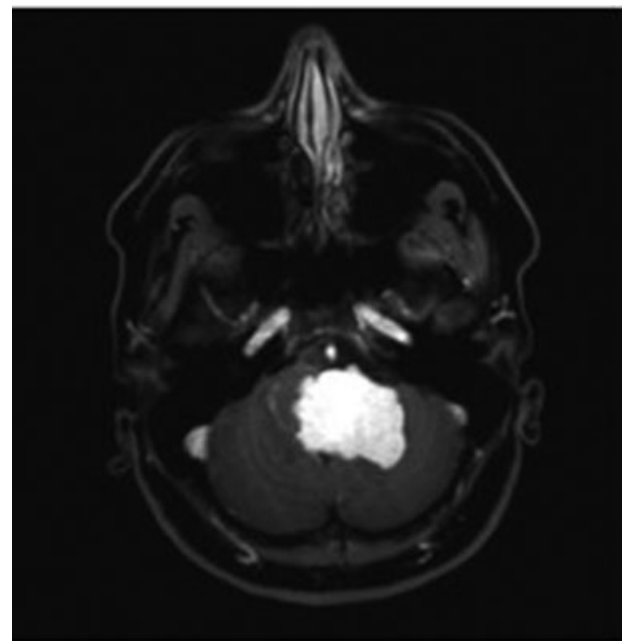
Encephalon T1-weighted MRI scan with contrast showing tumor mass in the region of the fourth ventricle, with homogeneous enhancement and significant mass effect on the brainstem in the axial section.
